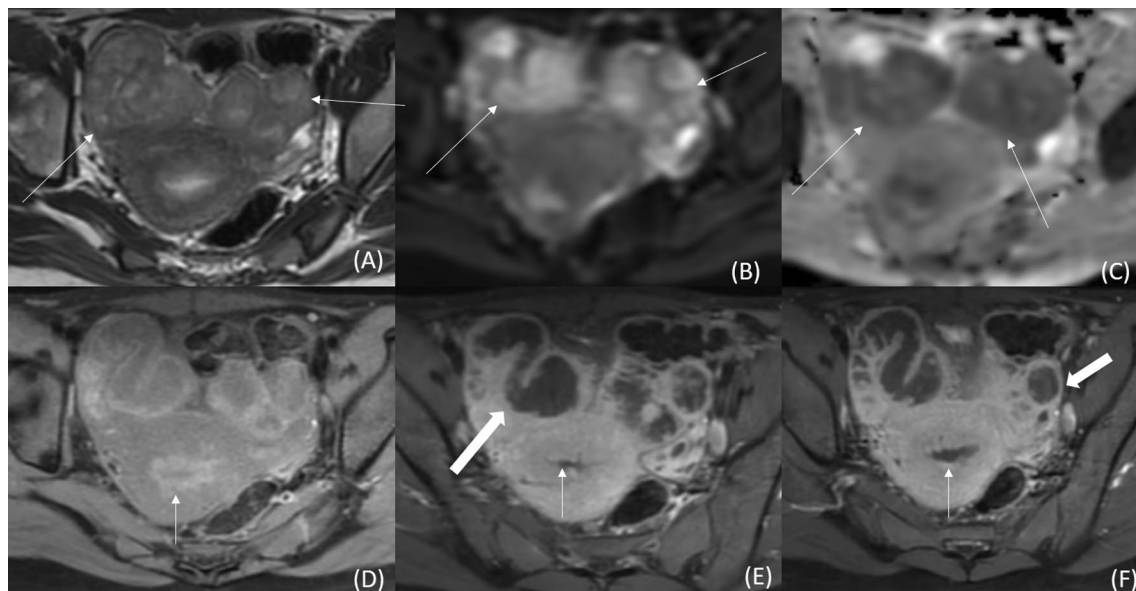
Female genital tuberculosis—endometritis and bilateral pyosalpinx. MRI pelvis of a 16-year-old girl shows dilatation of bilateral fallopian tubes with hyperintense contents and fluid in endometrial cavity on T2W image (A), contents of bilateral fallopian tubes show restriction (B and C), T1W fat-suppressed (D) and T1W contrast-enhanced images (E, F) show irregularity of endometrial lining (thin arrow) and thick peripheral enhancement of bilateral fallopian tubes (solid arrow in E, F)
